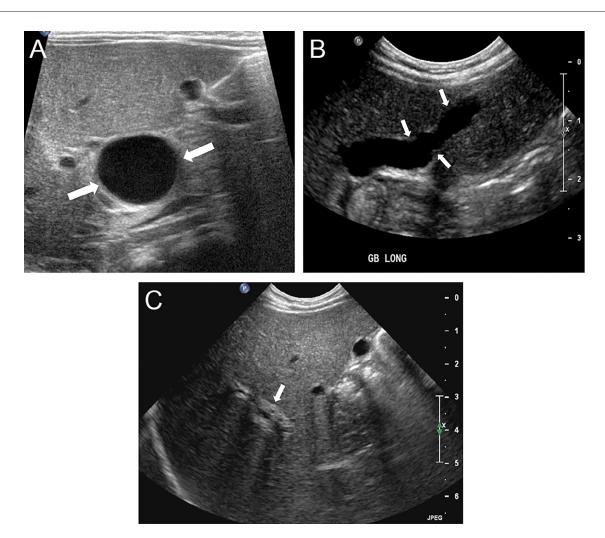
(A) Transverse grayscale sonographic image in the porta hepatis shows a round cyst (arrows) with anechoic internal fluid. (B) Longitudinal grayscale sonographic image demonstrates an elongated gallbladder measuring greater than 1.5 cm in length that has irregular walls and luminal narrowing (arrows). The distal aspect of the gallbladder was intrahepatic. (C) Transverse grayscale sonographic image of the right lobe of the liver reveals abnormal echogenic thickening (>4 mm) along the anterior wall of the right portal vein (arrow), the "triangular cord sign." Note the absence of intrahepatic biliary duct dilation.
